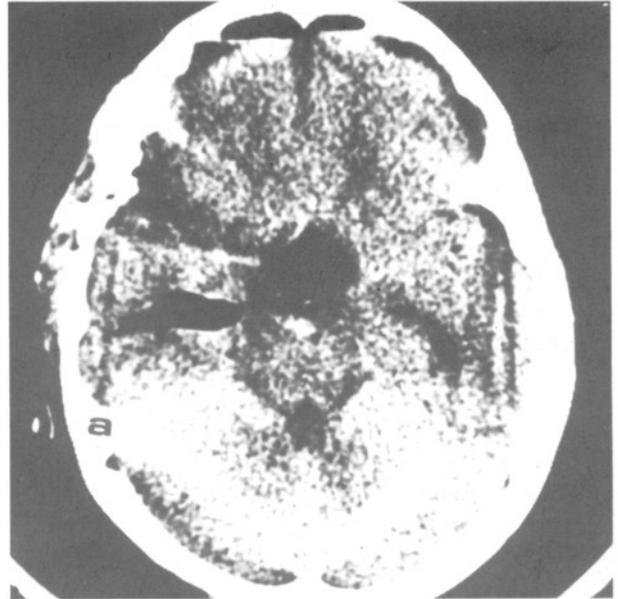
a,b: Postoperative CT scans showing almost total tumor removal.
